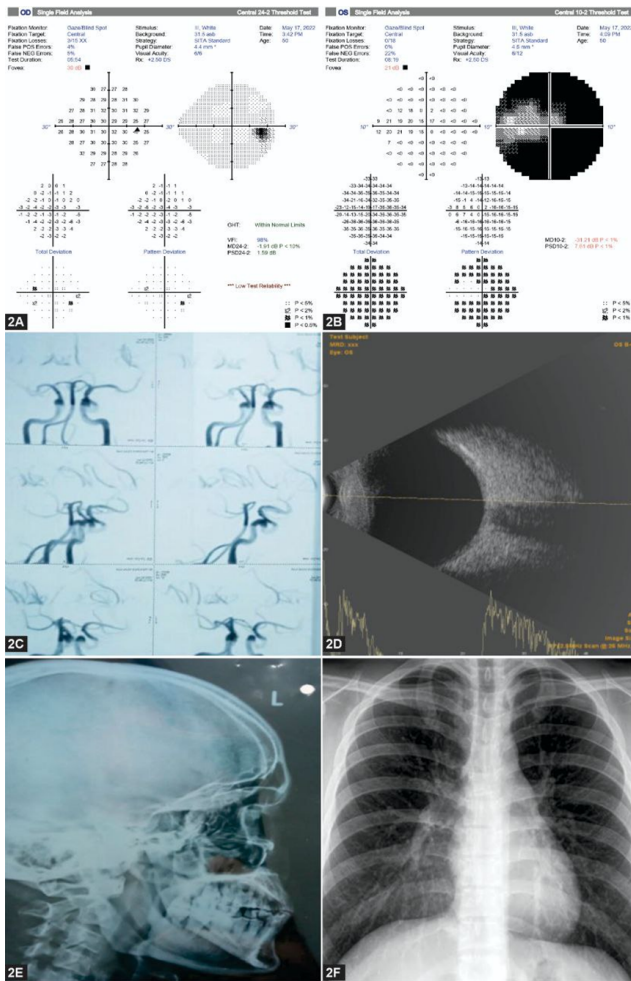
A): Right eye fields are normal; B): Left eye fields showing involvement of central 10 degree fields; C): Magnetic Resonance Angiography brain and orbit showed no evidence of tumor or arteriovenous malformations; D,E,F): B Scan, X-ray skull and x- ray chest were unremarkable
